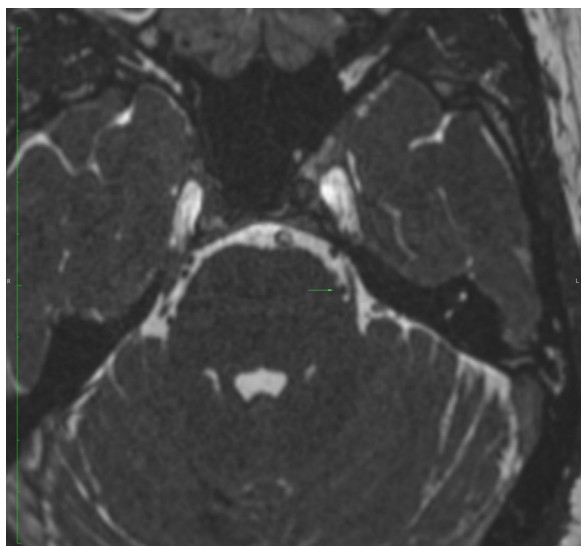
Pre-operative MRI of brain axial section B-SSFP sequence showing the SCA loop compressing the DREZ of trigeminal nerve
